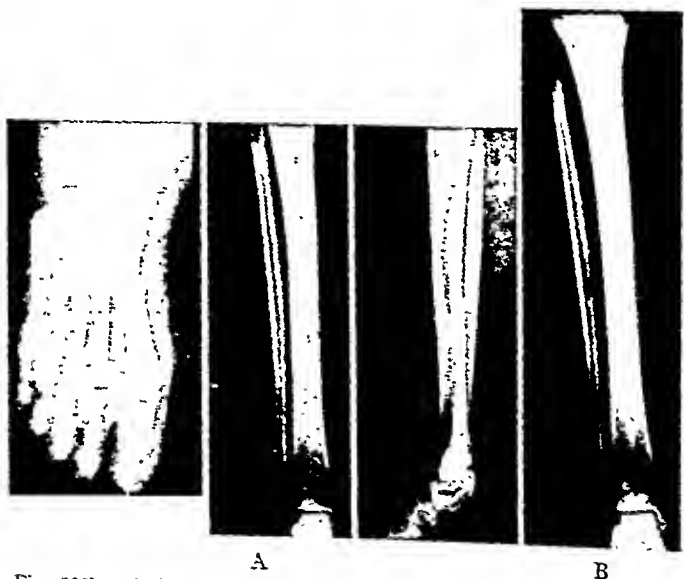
A. Pituitary basophilism. Rather large defects can be seen in the first, third and fourth metatarsal bones and in the first terminal phalanx. This film was made shortly after admission and before x-ray treatment. The sharply circumscribed defects in the tibia can be seen throughout the shaft of the bone. Roentgenograms made before treatment. B. Roentgenogram made nine months after a series of x-ray treatments to the pituitary gland. The demineralized areas in the tibia are so completely filled in by new bone that their original sites are difficult to determine. (Courtesy of Wohl, M. G., Moore, J. R. and Young, B. R.: *Radiology*, vol. 24.)
